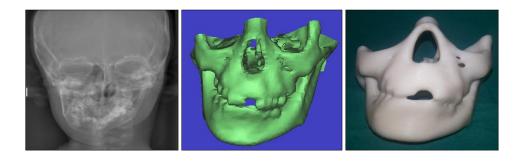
Manufacturing of patient specific AM model for preplanning of complex surgery, (CT scan, 3D CAD Model, AM Model), Source: (Kumar *et al.*, 2017)
